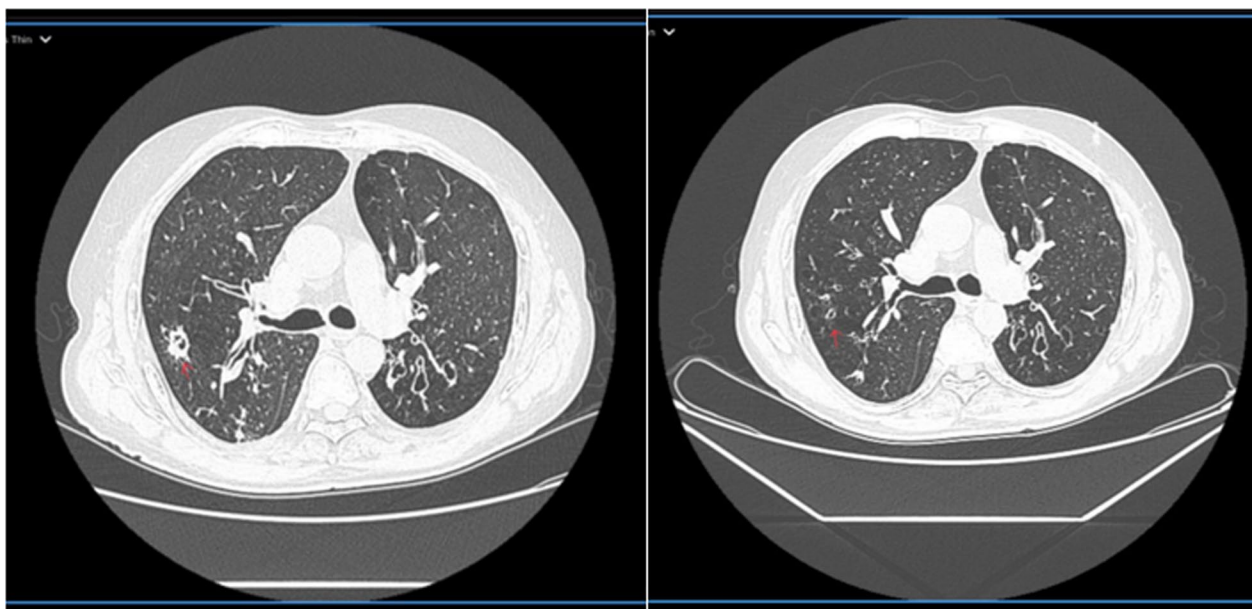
The red arrow in figure on left side shows a consolidation patch. Figure on right side is follow up CT at 02 months. Red arrow shows resolution of consolidation
